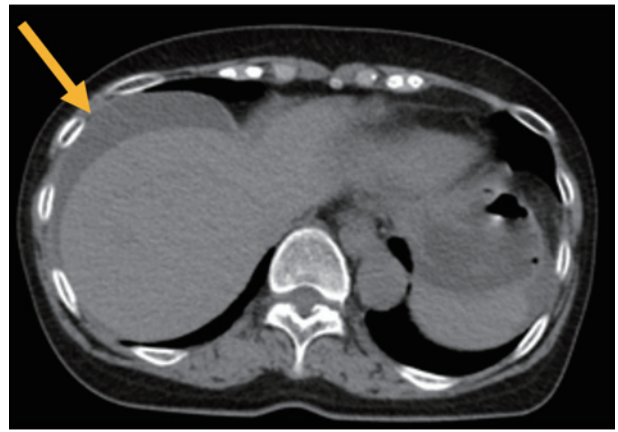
Abdominal computed tomography showing ascites (arrow) on the liver surface.
